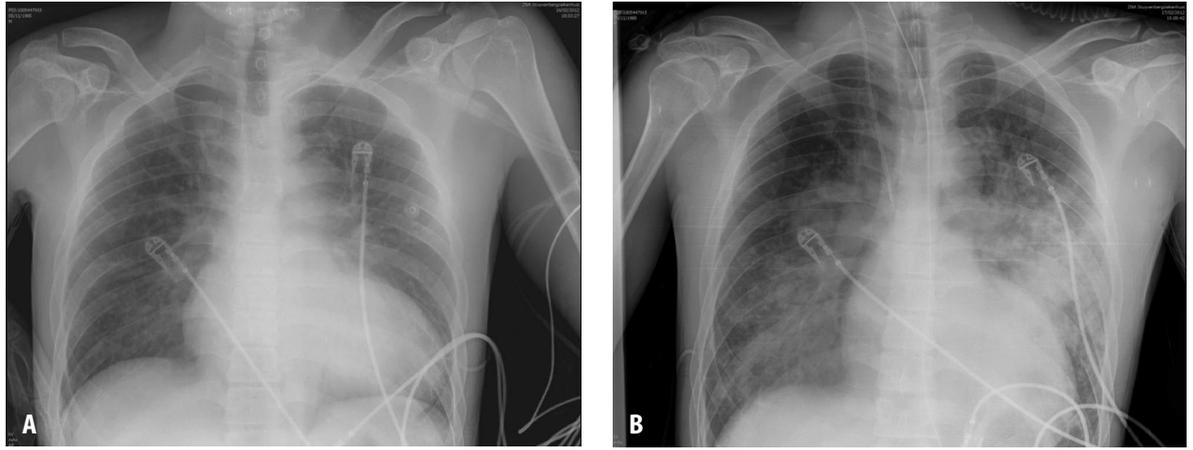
Panel A. Chest X-ray obtained at admission. Panel B. Chest X-ray after 18 hours, obtained just after endotracheal intubation showing cardiomegaly with vascular crowding and bilateral interstitial infiltrates.
